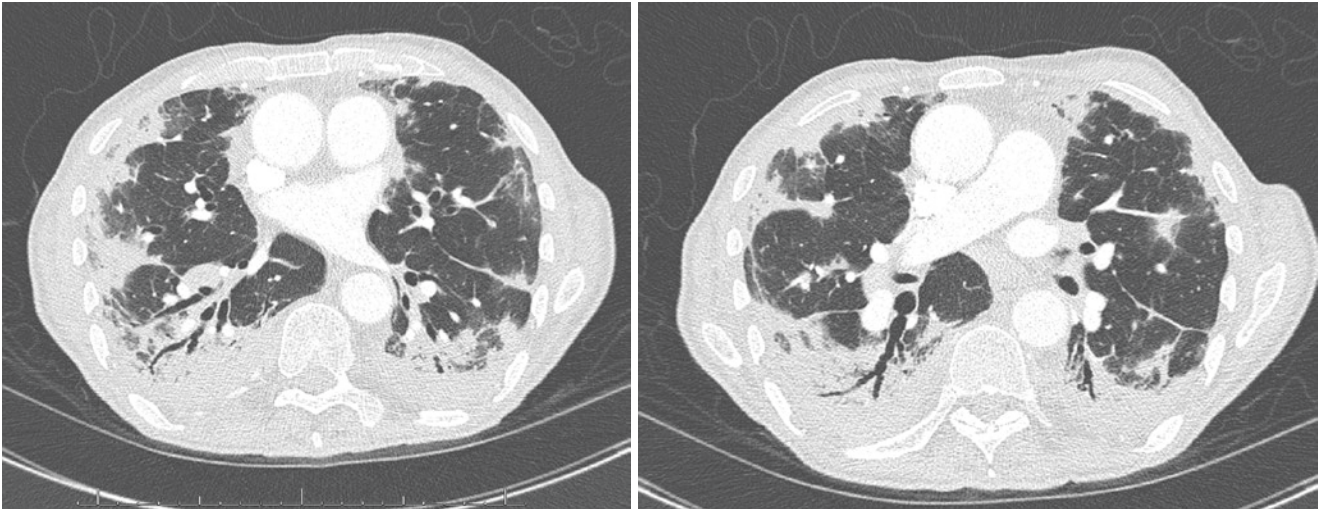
CT scan of lungs without intravenous contrast showing cavitary pneumonia with dense consolidation involving both lower lobes in a patient with GVHD, who developed infection due to dematiaceous mold following allogeneic HSCT. In the differential diagnosis, necrotizing bacterial, clear (hyaline) and black (melanin pigmented) mold infections should also be considered along with multifocal pulmonary nocardiosis
